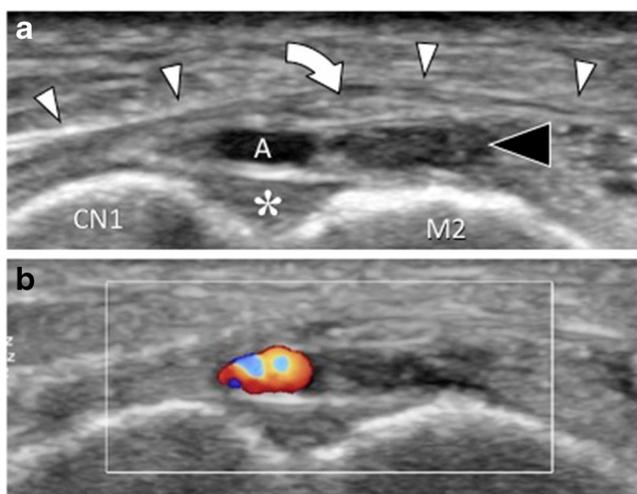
A 70-year-old woman with compression of the MBDFN at the Lisfranc joint (patient 4). Color Doppler appearance. Greyscale (a) and color Doppler (b) axial oblique sonograms were obtained over the site of compression of the MBDFN. a The neuroma superiorly displaces the extensor hallucis brevis tendon (curved arrow) and the superficial fascia (white arrowheads). b The dorsalis pedis artery (A) shows a normal size and internal flow
